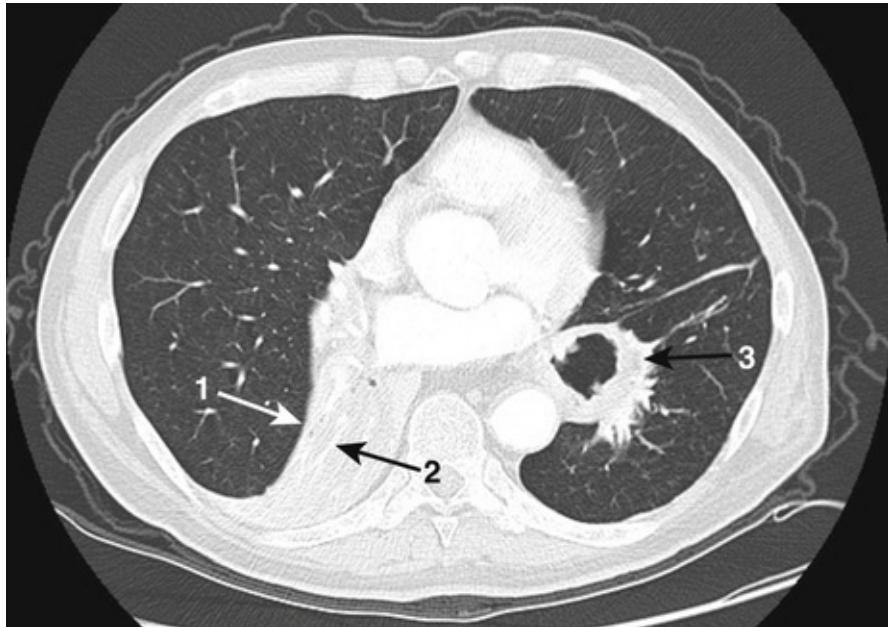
Right lower lobe collapse. Image shows the appearance of right lower lobe collapse on the lung windows of a CT scan. There is a wedge-shaped opacity (1) with curved edges in the right lung fanning out from the hilum towards the posterior part of the chest wall. No air bronchograms can be seen within. Contrast can just be made out in the blood vessels of the collapsed lung (2). The air-filled structure on the left is gas within the stomach under an elevated diaphragm (3), an unrelated finding.
